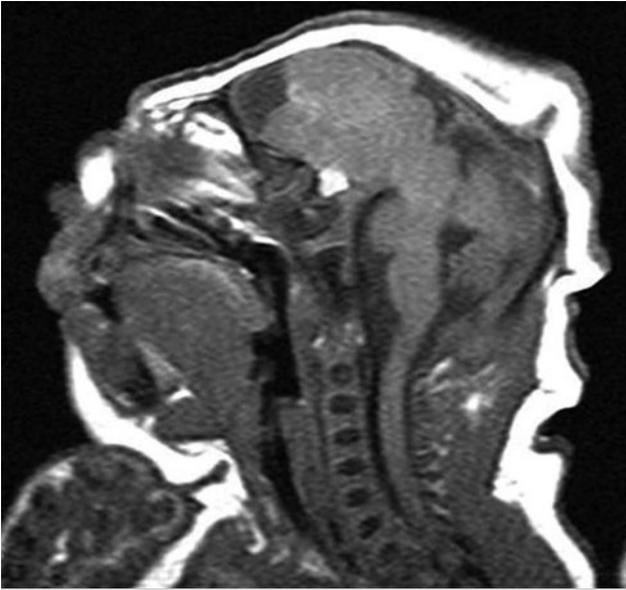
Sagittal T1-weighted magnetic resonance image of a neonate born with anencephaly. All of the occipital and parietal lobes and most of the frontal lobes are degenerated. The posterior fossa structures are nearly intact. Note the proptotic eye and recessed forehead.
